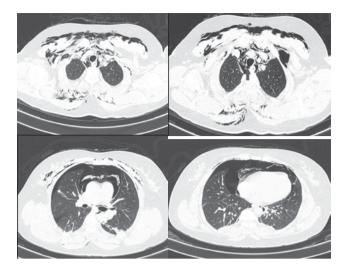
HRCT chest done at ER. Blue arrow showing rupture of lower part of posterior tracheal wall along with pneumomediastinum, pneumothorax and soft tissue emphysema
